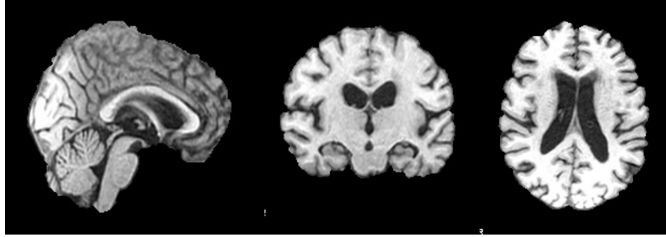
MRI after slicing
